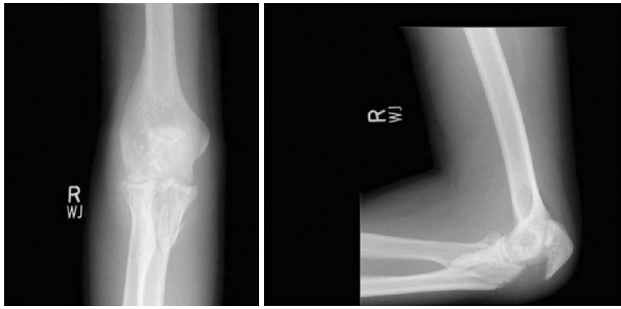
AP and lateral radiographs of elbow showing fracture of olecranon process and associated multiple small, round sclerotic lesions of variable sizes.
